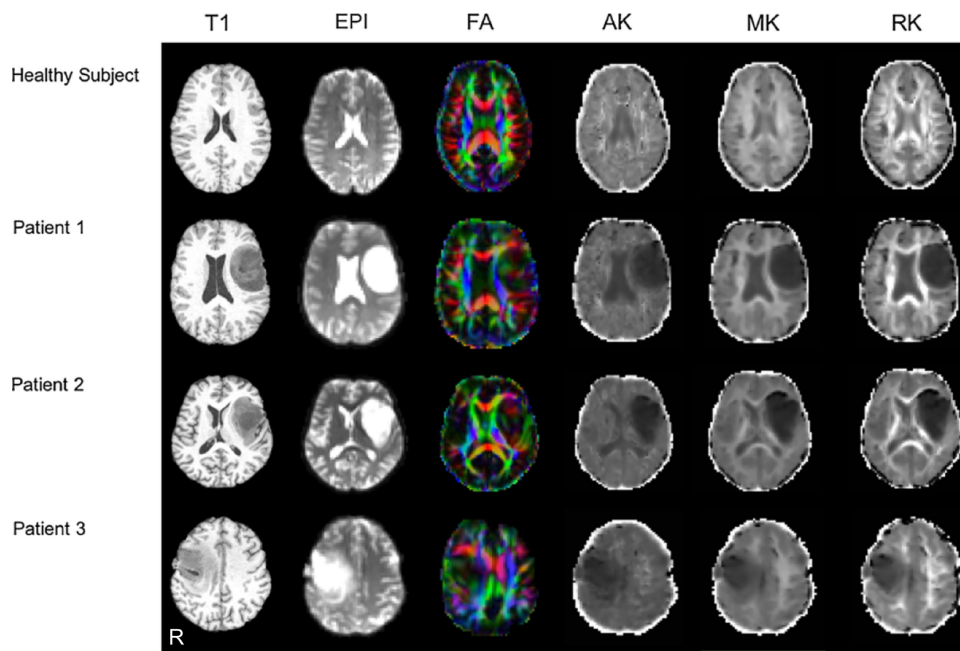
Transverse T1-weighted images (T1), echo planar images (EPI), fractional anisotropy (FA) maps and diffusion kurtosis invariant metrics (AK: axial kurtosis; MK: mean kurtosis; RK: radial kurtosis) maps of a healthy subject and patients with gliomas. In patients, anatomical scans (T1) were contrast-enhanced. Note the distortion of the fibres with cranial-caudal direction (i.e. colored in blue) produced by the tumor in the pathological hemispheres.
